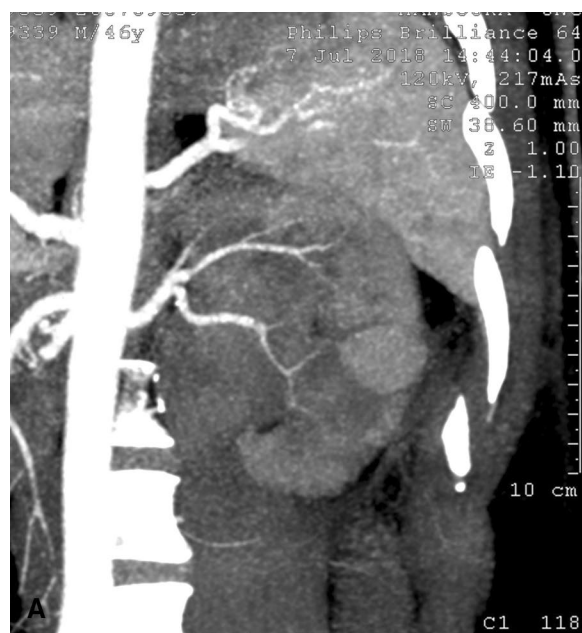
Coronal CTA of left kidney in a 46-year-old male patient with hematuria after PCNL showing pseudoaneurysm from segmental lower branch (A). Selective left renal angiography of the same patient revealed the same findings (B)
